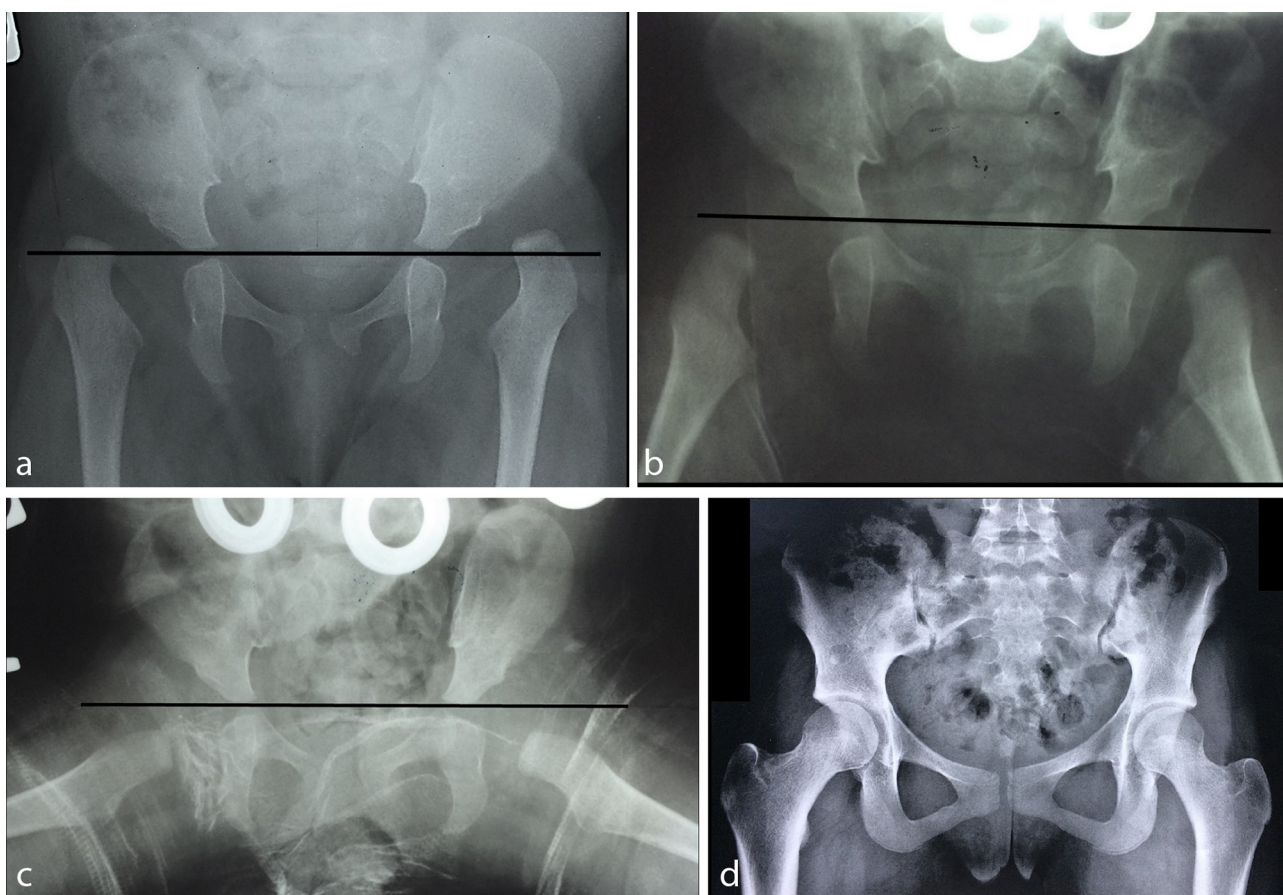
Bilateral developmental dysplasia of the hip in a six-month-old girl: (a) initial radiography – notice the high position of the proximal femur relatively to the Hilgenreiner's line; (b) step 1: notice the descent of the proximal femur; (c) step 2: abduction and internal rotation; (d) result at 16 years old (Severin I - without surgery).
